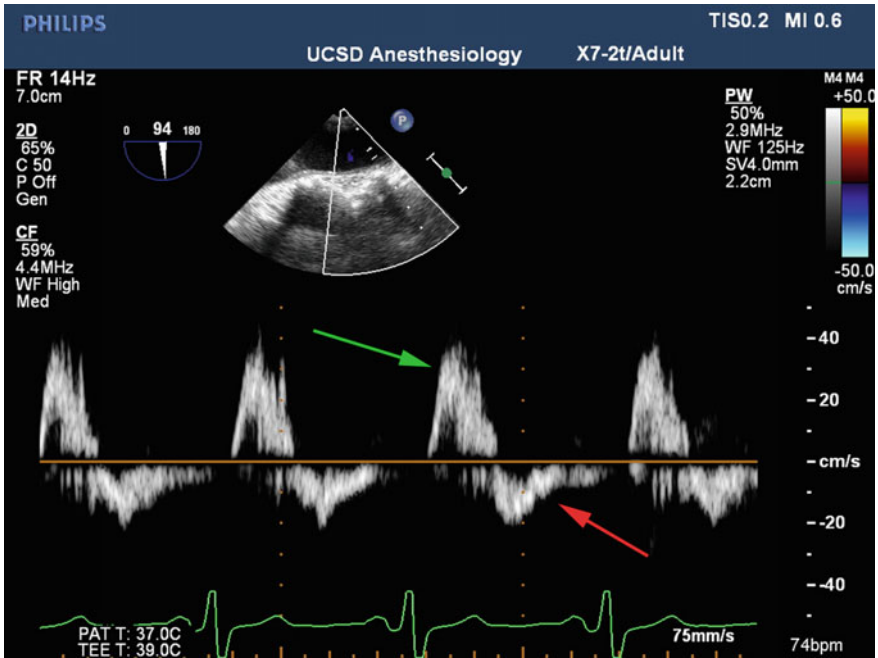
Descending aorta reversal of flow: a long axis of the descending aorta is obtained, and a pulse wave Doppler beam is placed within the aorta. The waveform demonstrates normal systolic forward flow (*green arrow*), however holodiastolic flow reversal (*red arrow*) is noted indicative of severe aortic regurgitation
